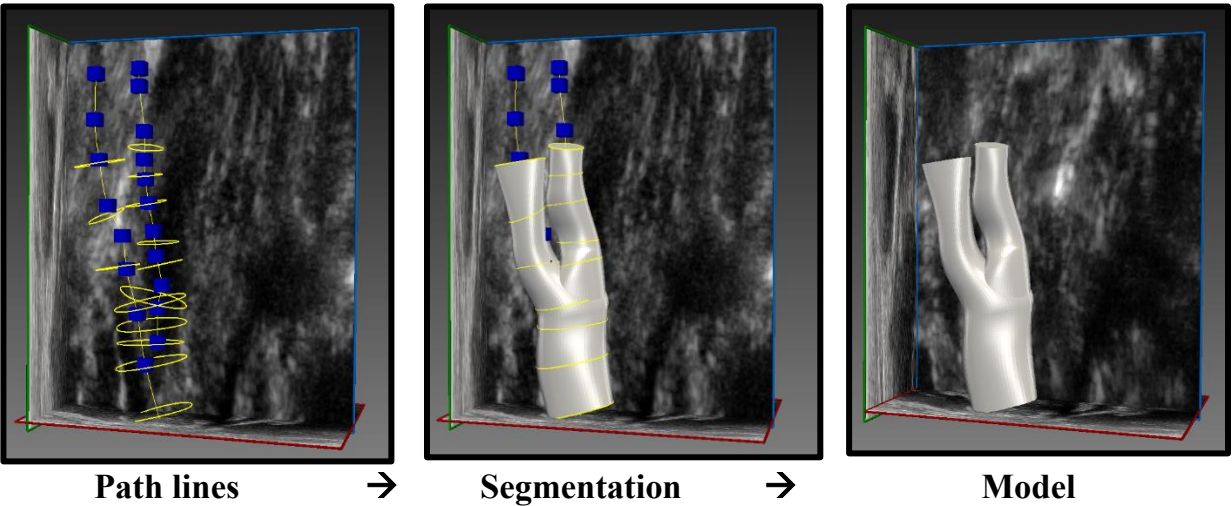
3D ultrasound images have been segmented and built to create 3D volumetric models. They were created by making a path line, segmenting the regions of interest, and then smoothing the model. Created on SimVascular software.
